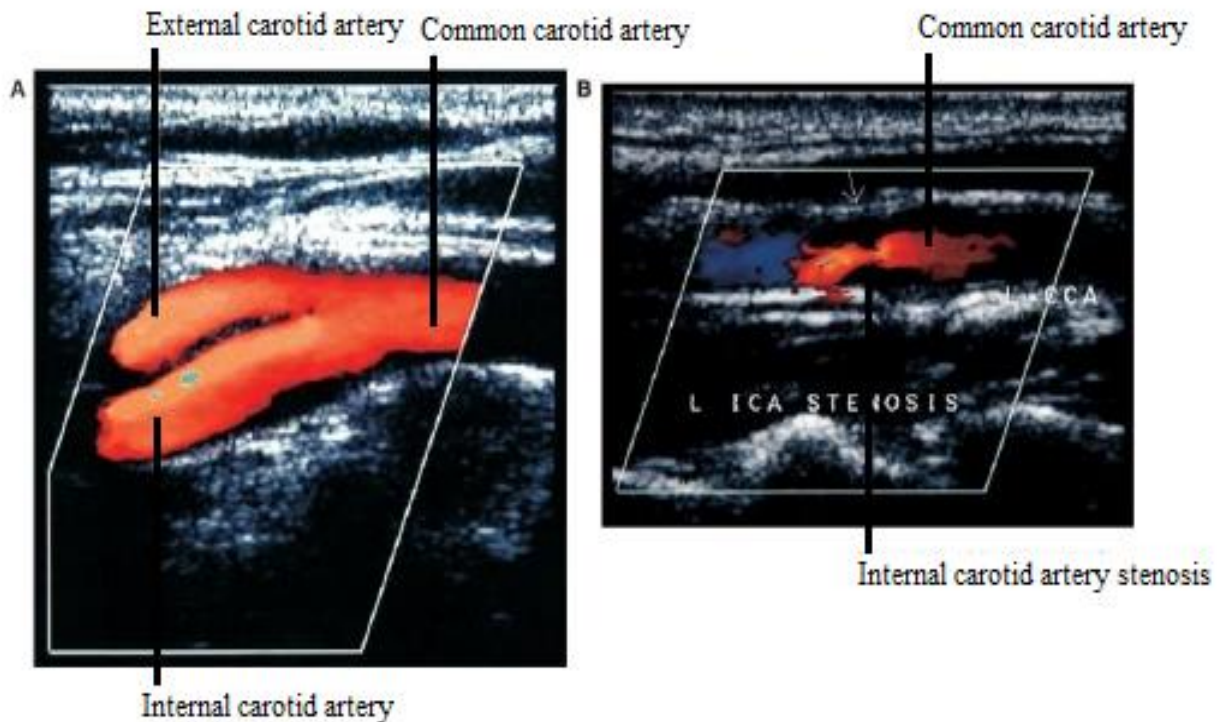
Ultrasound scans. A – Normal carotid bifurcation. B – Internal carotid artery stenosis.
